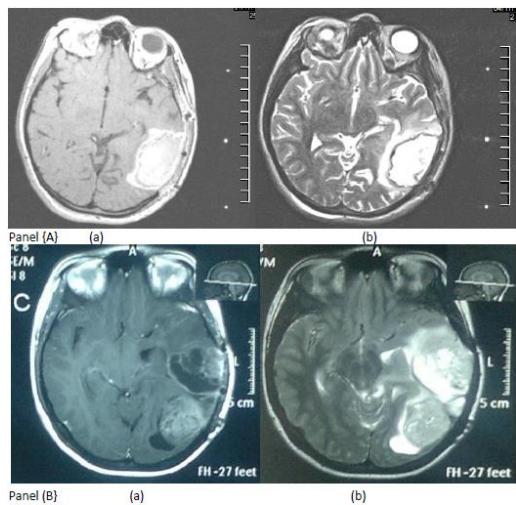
MRI Brain: Panel A (a) Axial T1 with contrast and (b) Axial T2 at initial diagnosis; Panel B (a) Axial T1 with contrast (b) axial T2 images at the time of recurrence.
